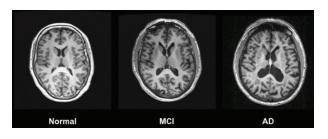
MRI images of MCI and AD compared to that of a healthy brain
